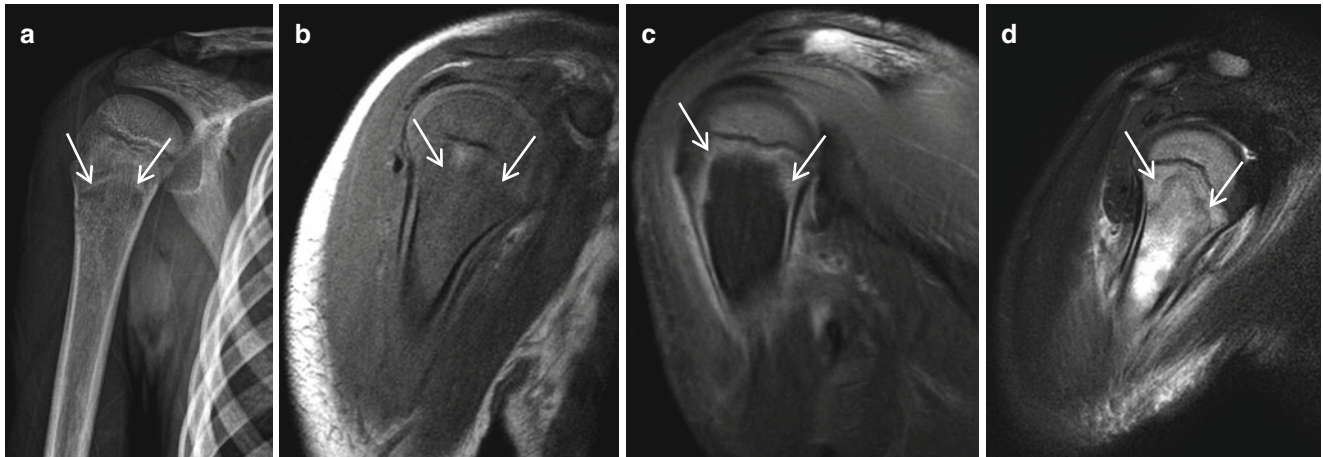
A 6-year-old boy presented with the pain of right humerus. He had chemotherapy due to leukemia. (a) Osteolytic lesion (*arrows*) in humerus. (b) Low-signal-intensity lesion in the T1-weighted MR
